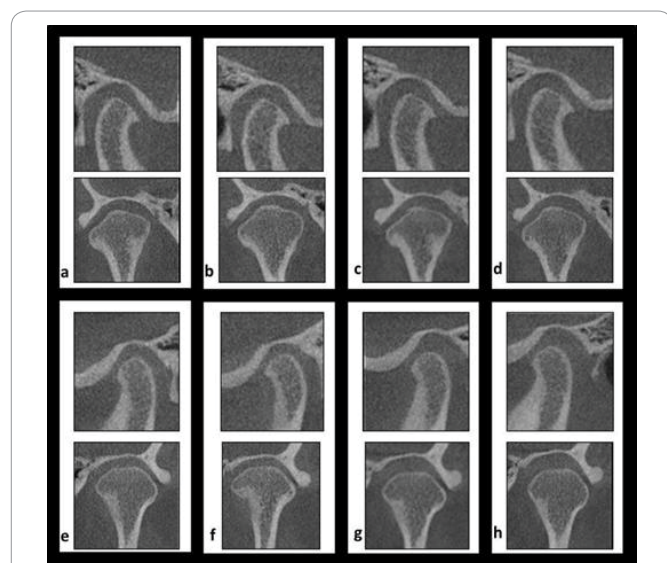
TMJ CBCT images: Left TMJ in sagittal and coronal cuts (a- rest position; b- MHI without splint; c- occlusion in 1mm splint; d- occlusion with 3 mm splint). Right TMJ in sagittal and coronal cuts (e- rest position; f- MHI without splint; g- occlusion in 1mm splint; h- occlusion with 3 mm splint).
